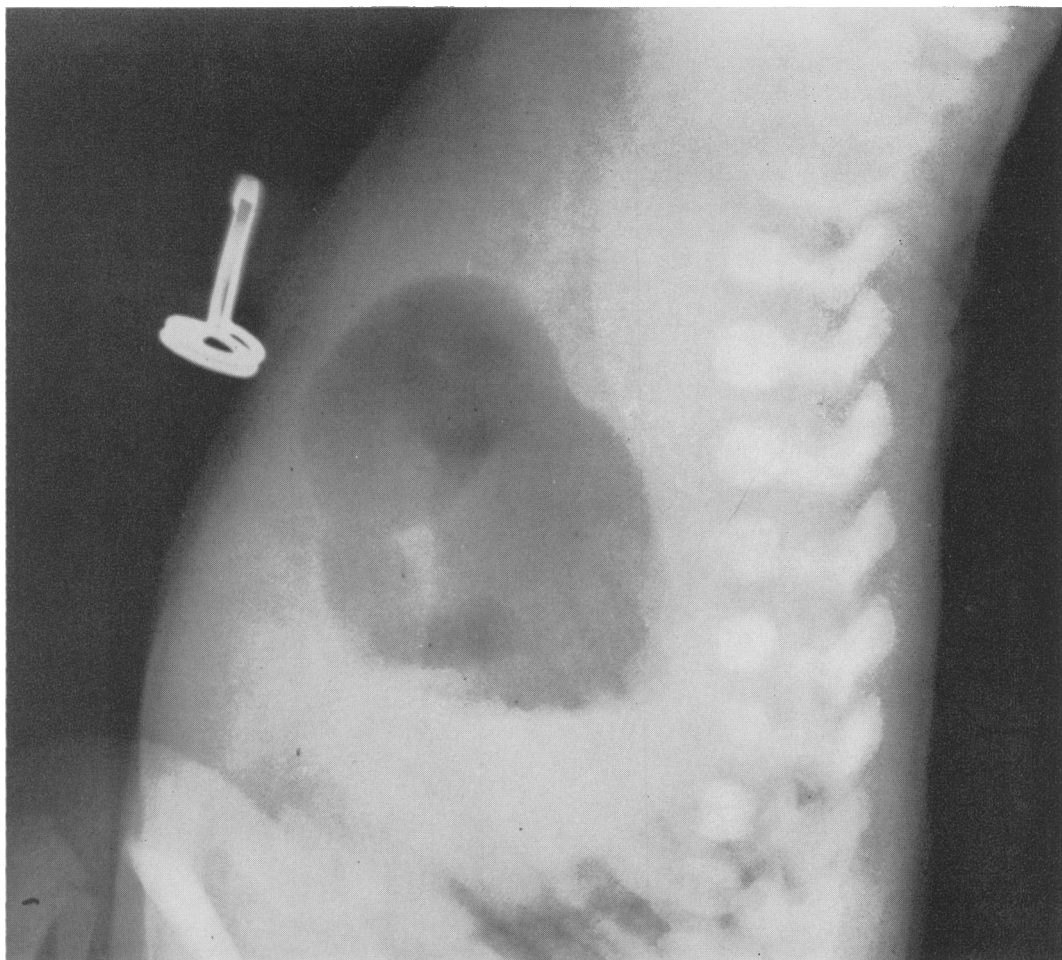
One-day-old male infant (Case 5) with an imperforate anus noted at birth. X-ray exposures in the inverted position incident to the discovery of this anal anomaly revealed the detailed study of the obstructed second portion of the duodenum noted in this lateral film.
